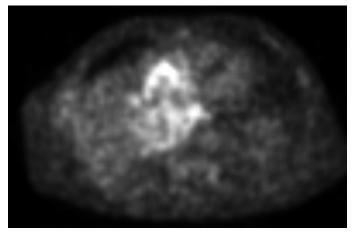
In PET-CT hypermetabolic mass lesion with heterogenous character, highly suspicious for malignancy, was detected in the mediobasal segment of the lower lobe of the right lung and in both atrial chambers to the heart.
